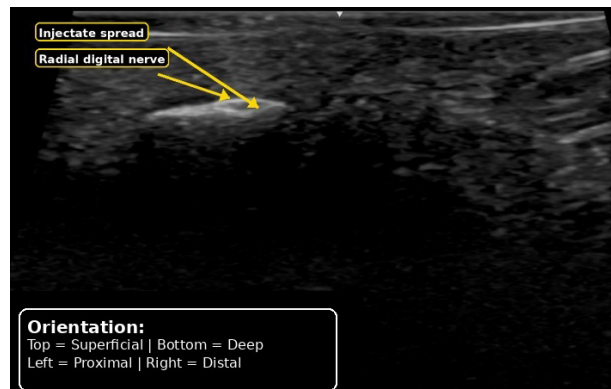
Ultrasound guided radial digital nerve block at the DIP level (transverse volar approach). Post injection image demonstrating spread of the 1.0 mL injectate surrounding the targeted perineural region.
